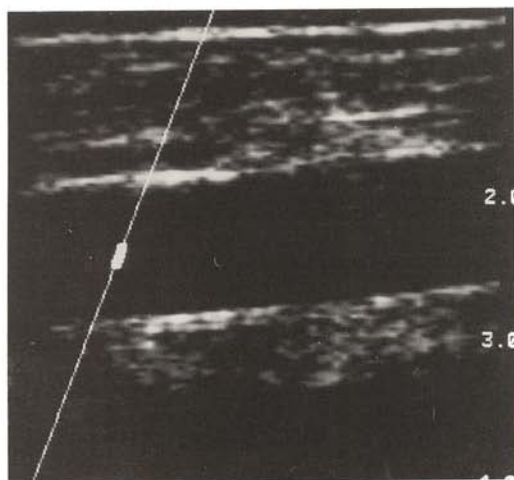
Placement of the Doppler cursor within the lumen of the vein in preparation for pulsed Doppler interrogation of venous flow.
